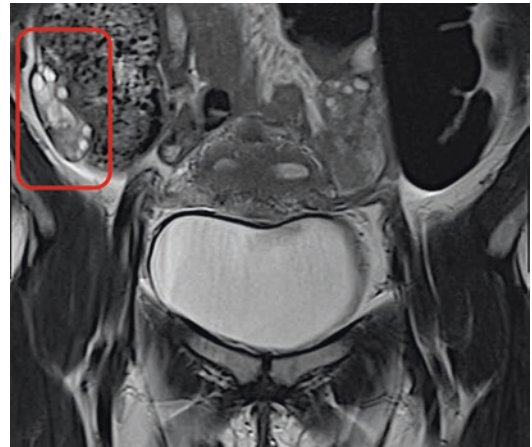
Magnetic resonance imaging, pelvic coronal view, right ovary after transposition in the right iliac fossa and uterine anterofixation before pelvic radiation therapy for a rectal cancer in a young woman
